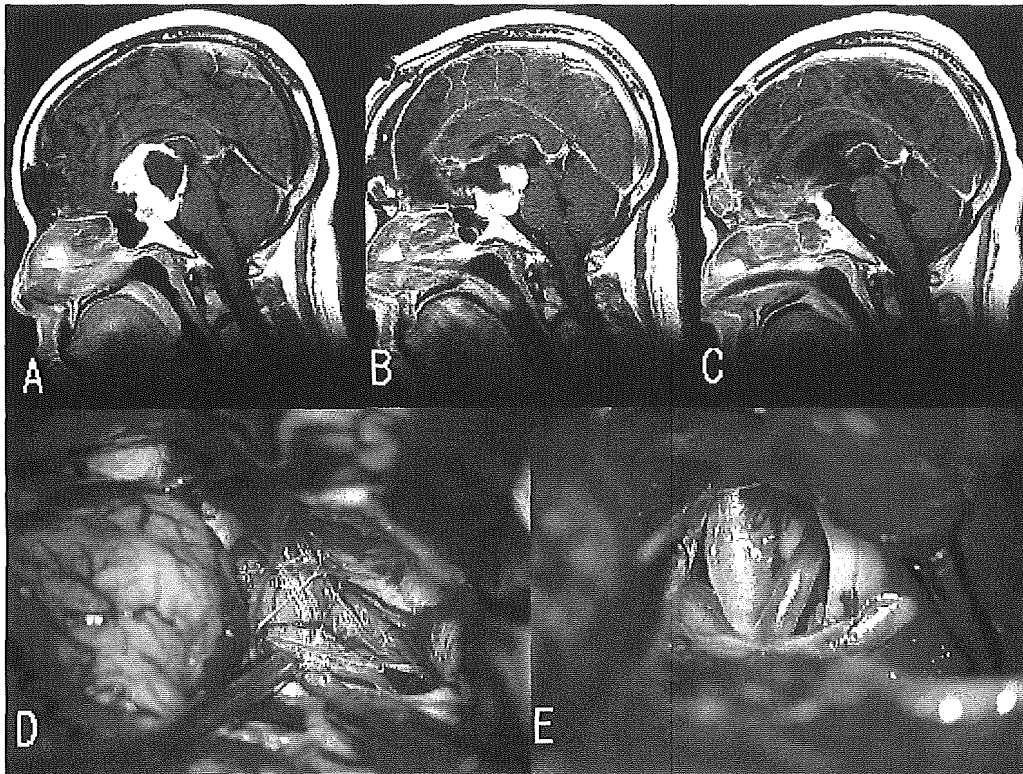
Case 5: (A): A sagittal image of gadolinium enhanced MRI showed a large suprasellar craniopharyngioma. (B): At the first operation through the anterior interhemispheric approach, the antero-superior part of the tumor was removed. (C): At the second operation through the transylvian trans-limen insular approach, the remnant tumor in the interpeduncular cistern was removed. (D): The operative view at the second operation. The tumor occupied the crural and ambient cisterns. Branches of the posterior communicating artery were identified on the tumor surface and were detached from the tumor. (E): The interpeduncular part of the tumor was removed and the basilar artery and the right superior cerebellar artery were exposed
